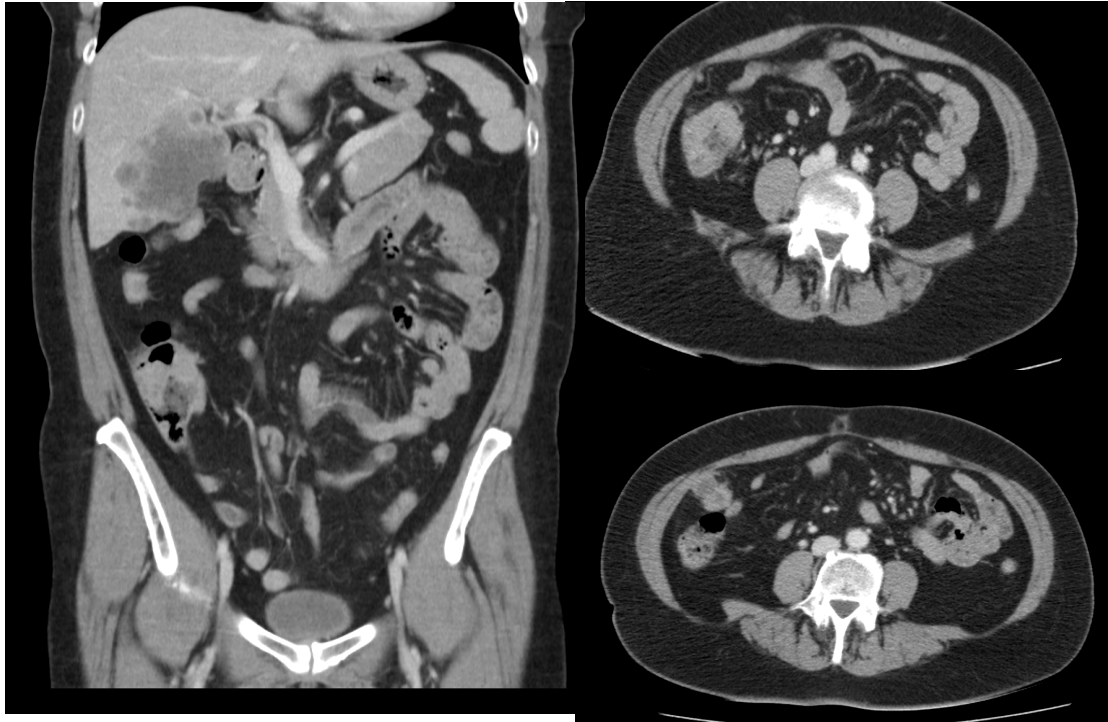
shows CT scan of the abdomen showing Caecal Cancer
